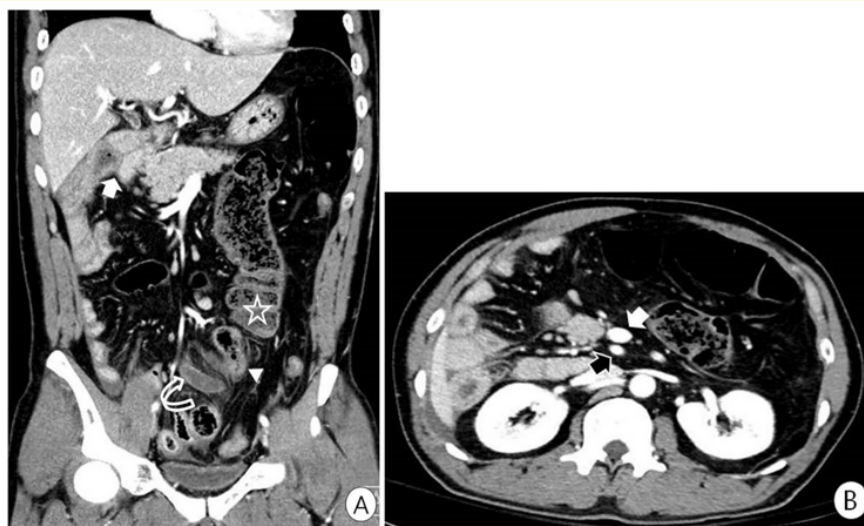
CT scan shows type 1a (non-rotation) midgut malrotation, (A) right sided duodenojejunal junction (arrow), left sided cecum (star) and terminal ileum (arrowhead) with midline appendix (curved arrow) and (B) inversion of superior mesenteric artery (black arrow) and superior mesenteric vein (white arrow).
